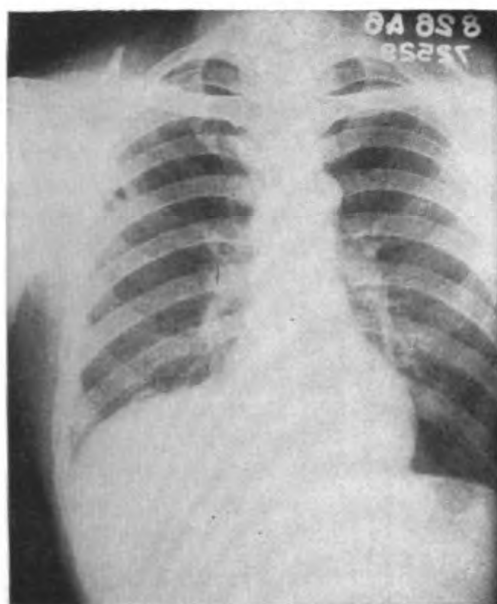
Case 3. During therapy. FIGURE 7.—Case 3. Final chest x-ray.
